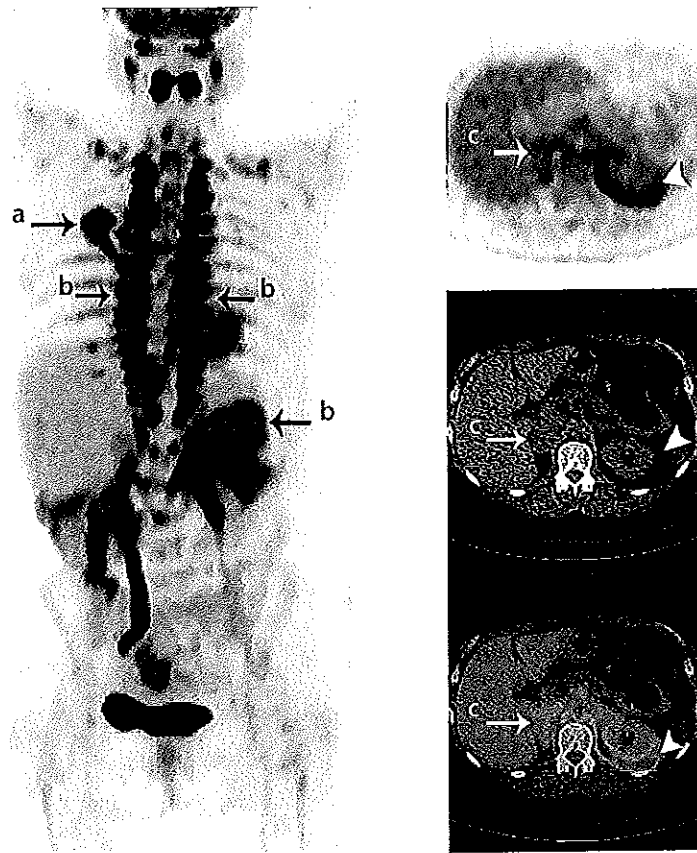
Severe brown adipose tissue activation due to an underlying phaeochromocytoma. MIP PET image in a patient attending for staging of a suspected lung cancer (a) shows intense brown fat activation in supra- and sub-diaphragmatic locations (b). Selected axial PET, CT, and fused PET/CT images depict a right adrenal mass that is mildly FDG avid (c). Biopsy revealed a phaeochromocytoma, with subsequent confirmation of elevated serum and urinary catecholamines. Note the avid brown fat uptake in the perinephric area (arrowhead).
